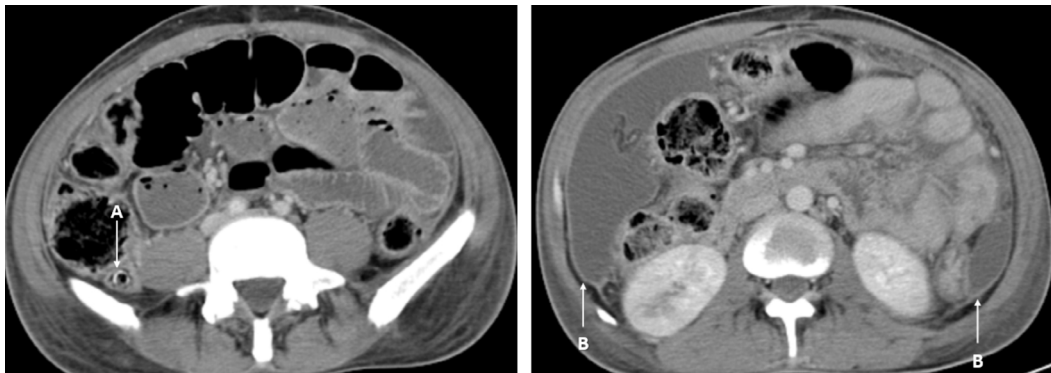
The axial contrast-enhanced computed tomography images of a 42-year-old female with perforated acute appendicitis, showing an intraluminal appendicolith (a), intraperitoneal ascites, diffuse abdomino-pelvic smooth peritoneal thickening, and peritoneal enhancement (b).
